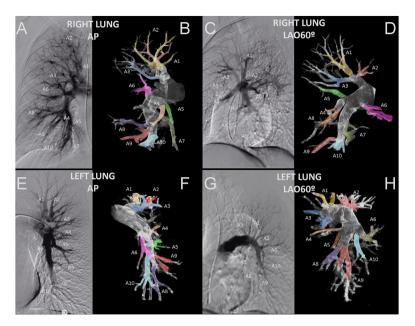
Pulmonary segments on usually used working angiographic projections during balloon pulmonary angioplasty (PA and LAO 60° projections). Digital subtraction pulmonary angiography (DSA-PA) and three-dimensional reconstruction from cone-beam CT-pulmonary angiography (3D-CBCT-PA) in a 56-year-old woman with confirmed chronic thromboembolic pulmonary hypertension. (A-D) demonstrates DSA-PA AP (A) and left anterior oblique (LAO) 60° view (C), and 3D-CBCT-PA AP (B) and LAO 60° view (D) images of the right lung. (E-H) demonstrates DSA-PA AP (E) and LAO60° (G), and 3D-CBCT-PA AP (F) and LAO60° view (H) images of the left lung. Segments are labeled A1 to A10 and marked in colors in the 3D-CBCT-PA images.
